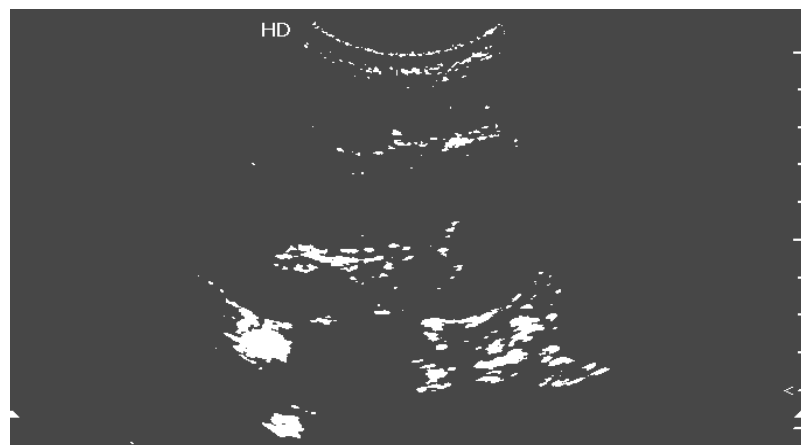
Ultrasonogram of the normal kidney. The kidney has a bean-shaped form, clear and smooth contours.
